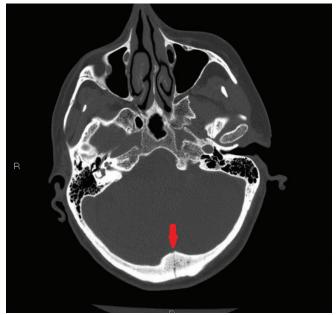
Bone window of an axial computed tomography scan of the head of a 68-year-old woman who was struck by an electric scooter, showing a nondisplaced occipital fracture, identified by the arrow.
